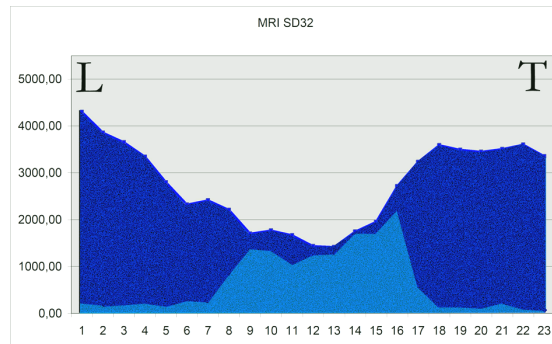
MRI (PD32). Upper curve: cord surface; lower curve: lesion surface. X-axis: MRI section number. Y-axis: surface (square pixels).
